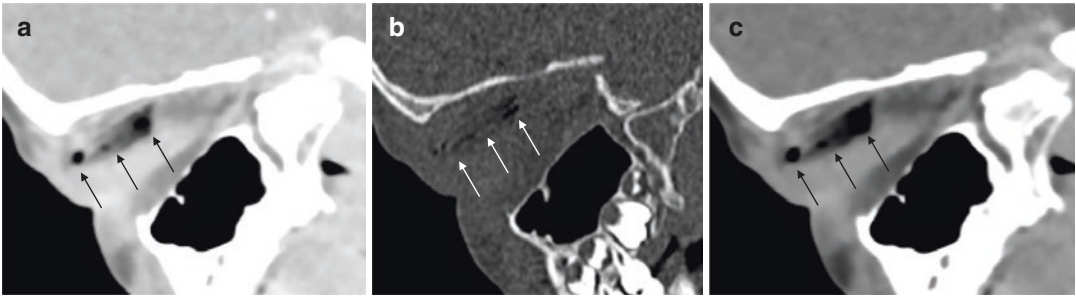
(a) Sagittal CT of the left orbit on lung window (a), bone window (b) and soft tissue window (c) settings. A geometric air containing foreign body (wood tree branch fragment) (black arrows) is lodged in the orbital
